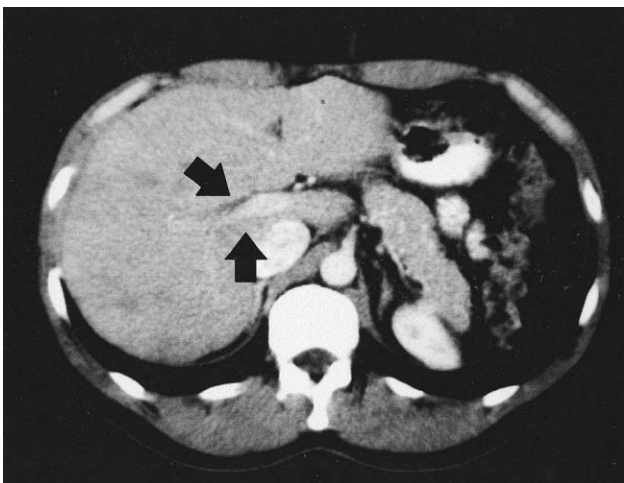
Computed tomography scan displays a complete thrombosis of the right portal vein (*arrows*) and hypoperfusion of the right liver.
